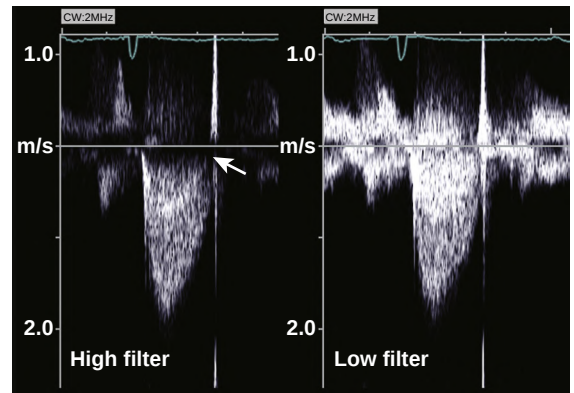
Wall filter settings. An aortic outflow signal is recorded with CW Doppler with the high pass ("wall") filter set at a high and low level. With the higher filter, low velocity signals are eliminated as shown by the blank space adjacent to the baseline (arrow). This tracing enhances identification of the maximum velocity and recognition of the valve closing click. At the lower filter setting, the velocity signals extend to the baseline, making measurement of time intervals more accurate, but there also is more low velocity noise in the signal, related to motion of cardiac structures.
